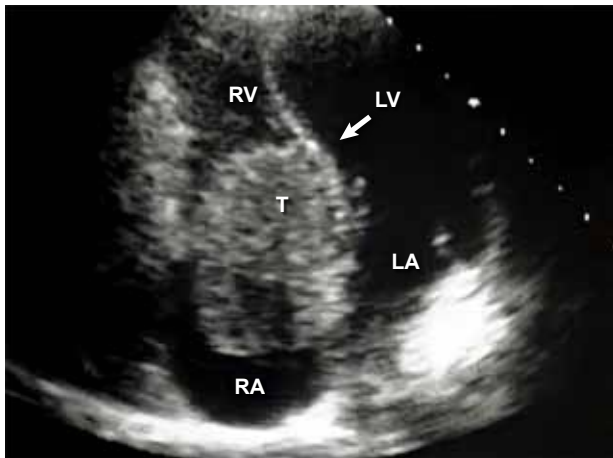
Transthoracic apical 4-chamber view of the heart in diastole showing a large right atrial tumor (T) prolapsing through the tricuspid valve and displacing the interventricular septum to the left (arrow). LA – left atrium; LV – left ventricle; RA – right atrium; RV – right ventricle.
